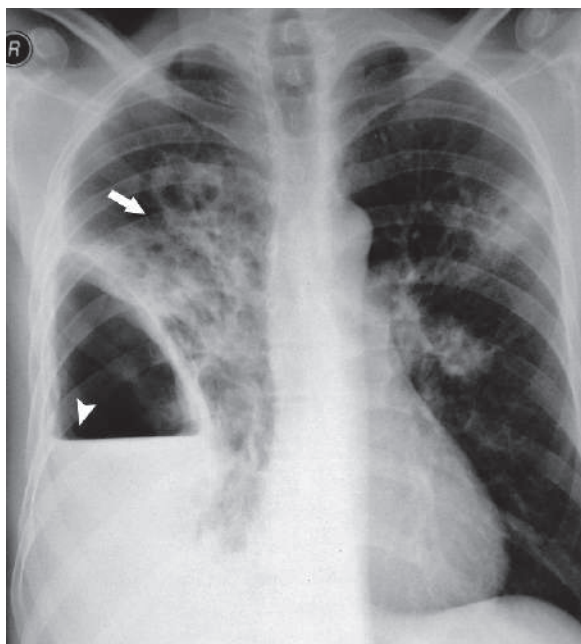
Posteroanterior plain chest radiograph in a patient with old TB and chronic empyema that transformed into a lung abscess shows a huge right lung abscess (*arrowhead*) and bronchiectasis (*arrow*). The patient needed several pleural taps, and the abscess was beginning to open into the right lateral chest wall
